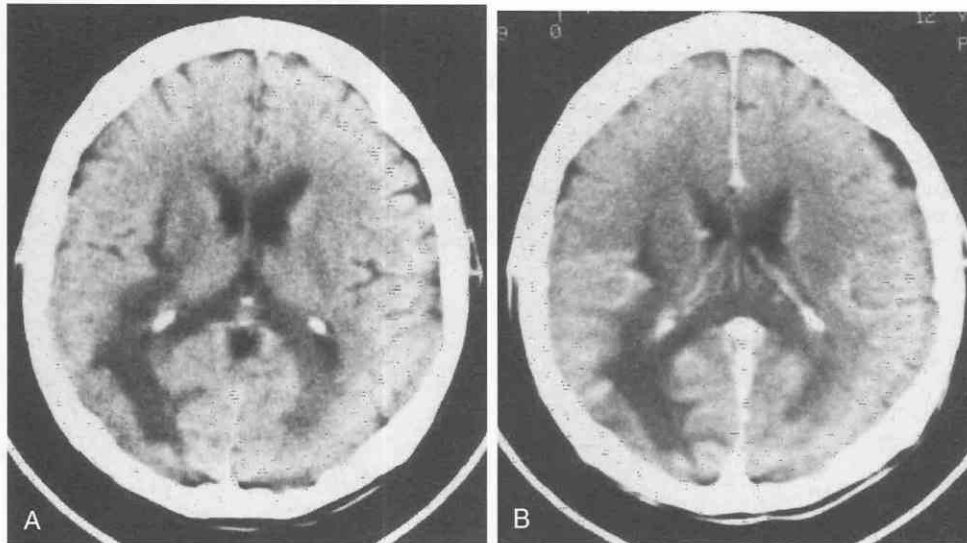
Progressive multifocal leukoencephalopathy (PML) associated with acquired immunodeficiency syndrome (AIDS). *A*, This non-contrast-enhanced CT scan, in this patient with rapidly progressive neurologic disease, shows a well-defined area of lucency in the right parieto-occipital white matter extending forward into the external capsule and medially into the splenium of the corpus callosum. Lesser involvement in the opposite occipital lobe is also present. *B*, Postcontrast image at the same level shows nonspecific enhancement of the overlying cortex but none within the white matter lesions. The diagnosis of PML was confirmed by biopsy.
